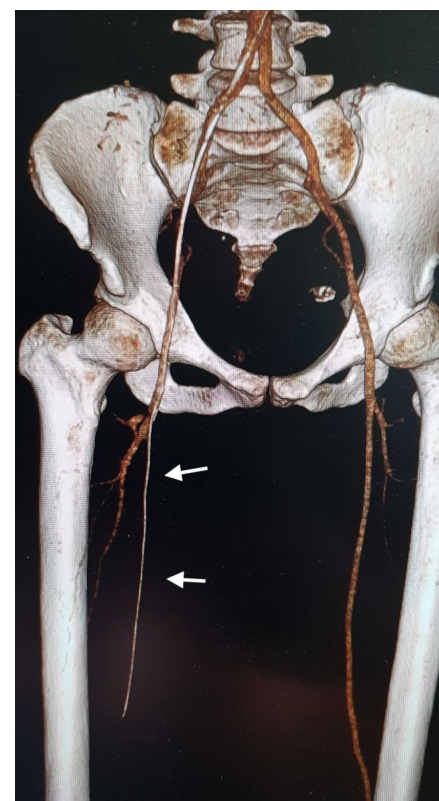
Computed tomography (CT) angiography with 3D volume rendering reconstructions of the lower limbs revealing a lengthy foreign body within the femoral/popliteal artery of the right leg.
